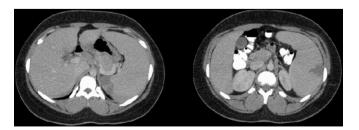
The initial contrast-enhanced CT scan of the abdomen and pelvis showing massive splenomegaly and several wedge-shaped areas within the periphery of the spleen consistent with multiple splenic infarcts.
